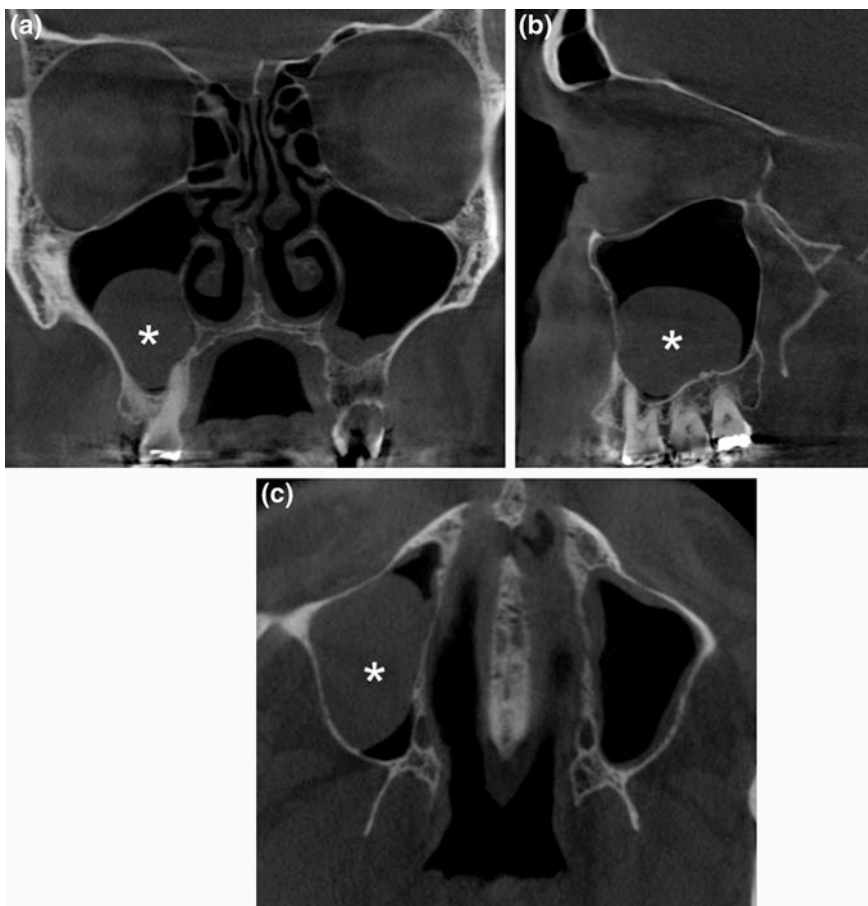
CBCT coronal (a), sagittal (b), and axial (c) sections demonstrating extensive soft tissue inflammation in the right maxillary sinus that appears like an antral mucosal pseudocyst, also called mucocoeles (*) and a thin mucosal thickening on the floor of left maxillary sinus. Also note that the nasal septum is deviated with convexity to the right
